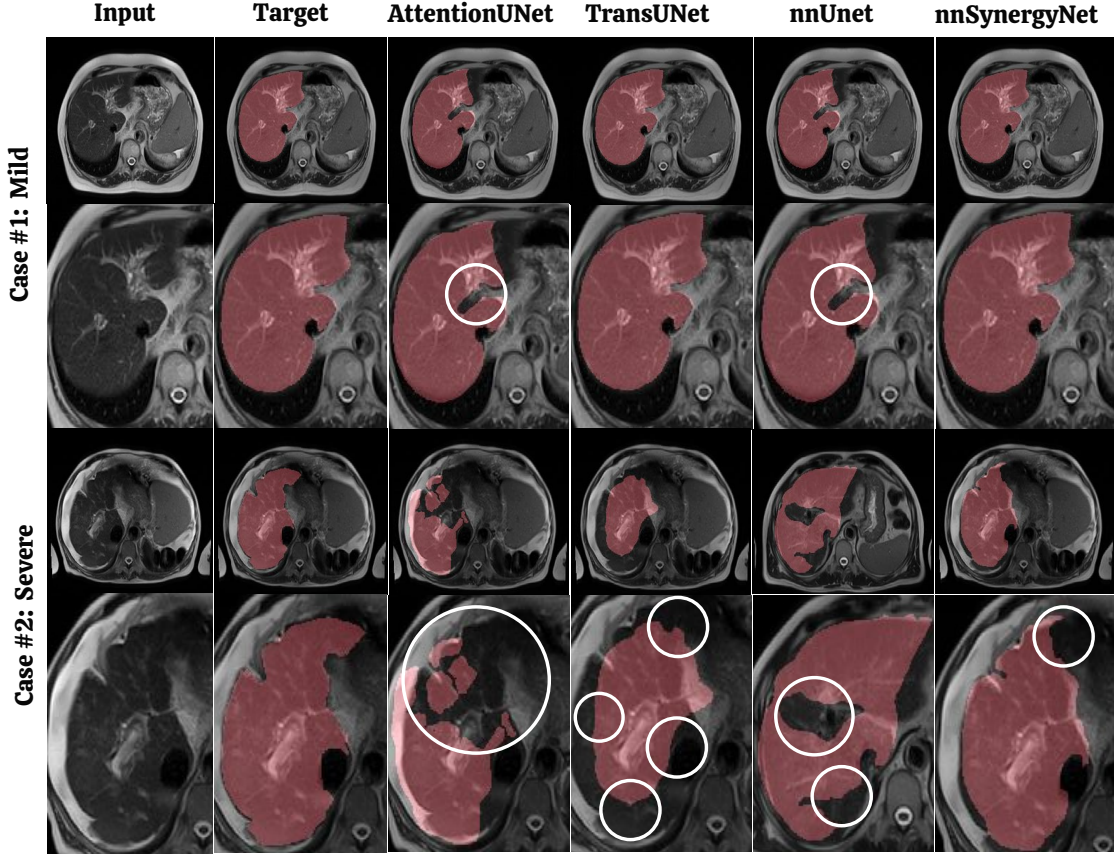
Qualitative results of different models on segmenting mild and severe cirrhosis from abdominal T2-weighted MRI scans. The white bounding circles show major errors made by the models.
